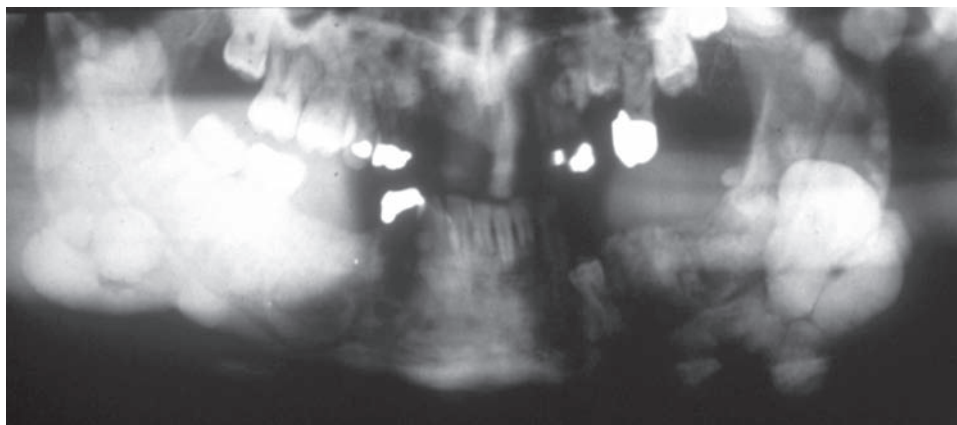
Gardner syndrome. The panoramic radiograph shows large osteomas involving the angle and ramus areas of the mandible bilaterally, a diagnostic feature. Several supernumerary premolar teeth are also seen.
